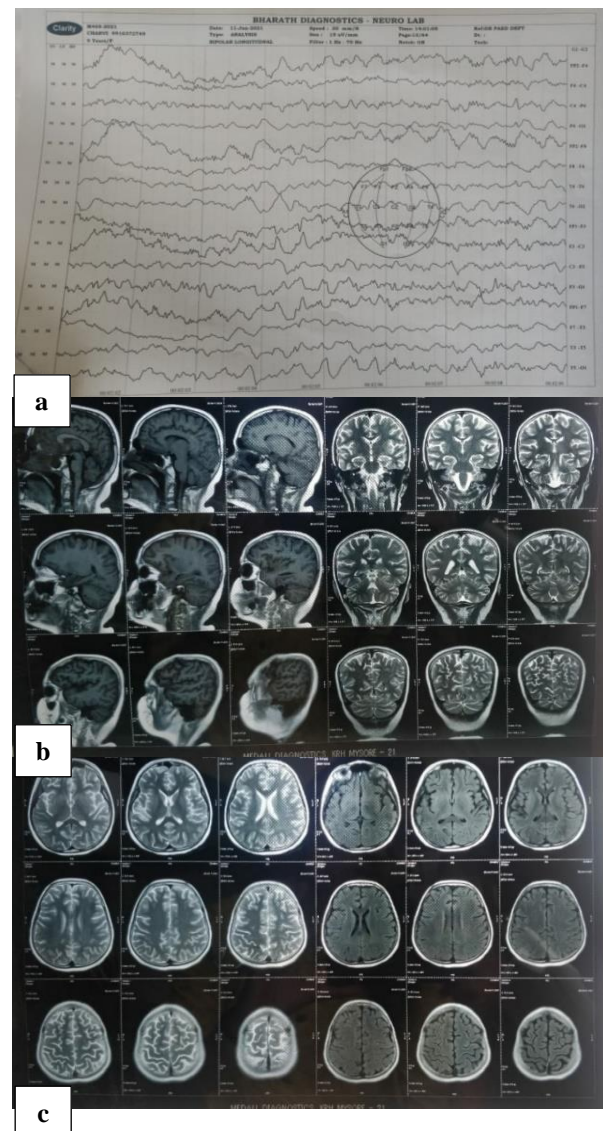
Neuroimaging of our child; (a) bedside EEG: delta brush pattern; (b and c) MRI brain of the child: showing normal brain parenchyma.
